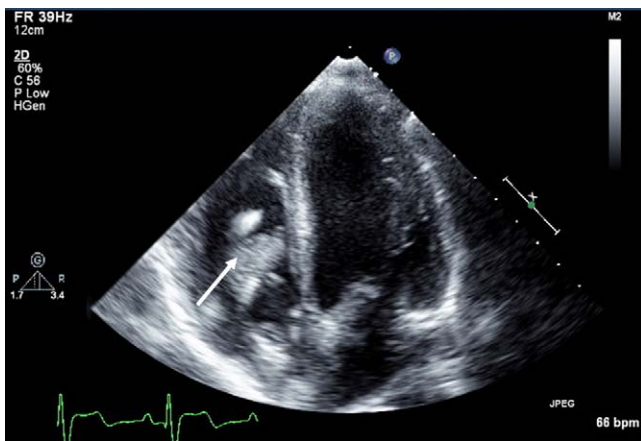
Transthoracic echocardiogram: 3.5 cm × 2 cm vegetation on the pacemaker lead and tricuspid valve protruding into the right ventricle (arrow).
